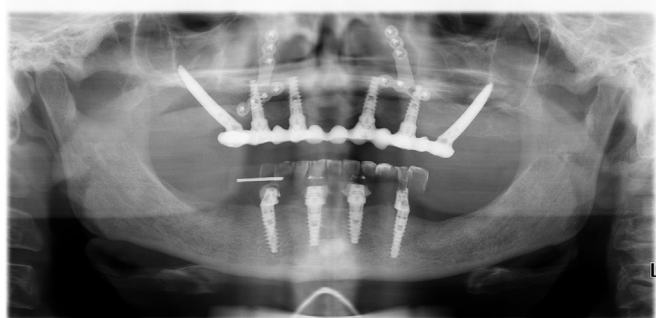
Panoramic X-ray of the patient after delivery of the final prosthesis. Note that zygomatic implants in association with orthognathic surgery were chosen in this case due to the atrophic situation of the posterior sectors, in association with severe dysmorphism of the maxilla. Given the severe hypoplasia of the maxilla, it was necessary to support the lip with a large and bulky gingival flange in order to achieve a desirable and esthetic prosthetic rehabilitation. Alternative treatments would have provided esthetic and functional results, for example improved chewing, but not to the extent achieved here. The rehabilitation options were discussed with the patient, and consequently planned according to their request for a better esthetic result.
